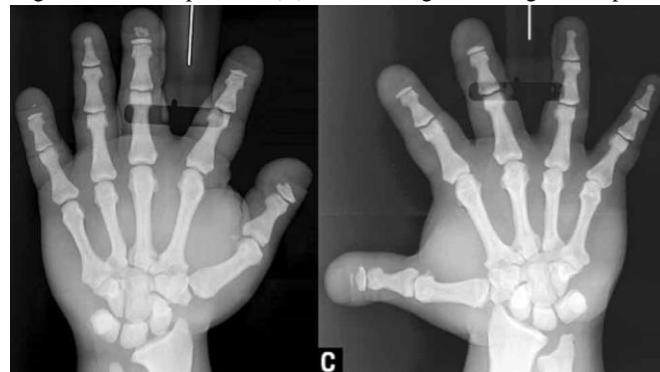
Hand and wrist radiographs showing the acro-osteolysis of the distal phalanges.
